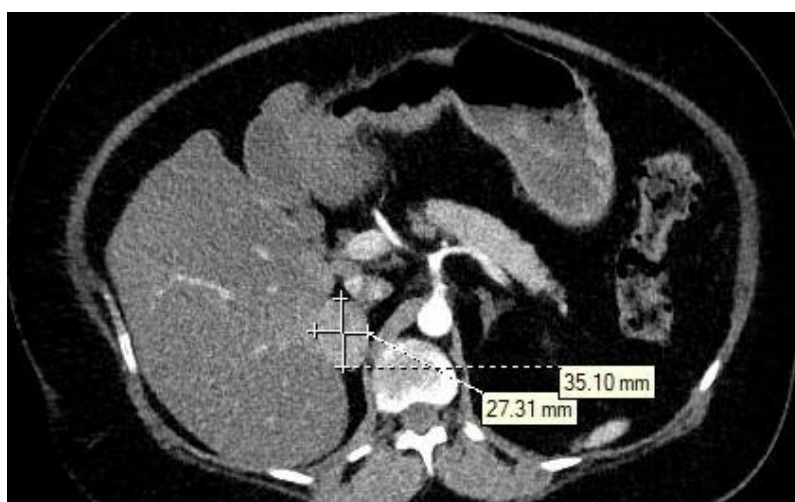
CT of abdomone with adrenal glan contrast protocol, there is seen adrenal gland adenoma with size of 35x27mm.
